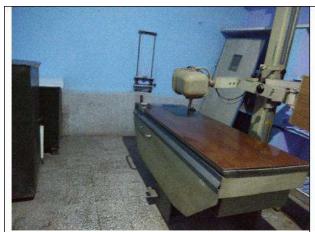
X-Ray Machine CHC Kairana
